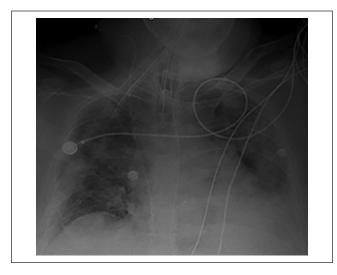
Chest X-ray showing patchy bilateral air space opacities.
